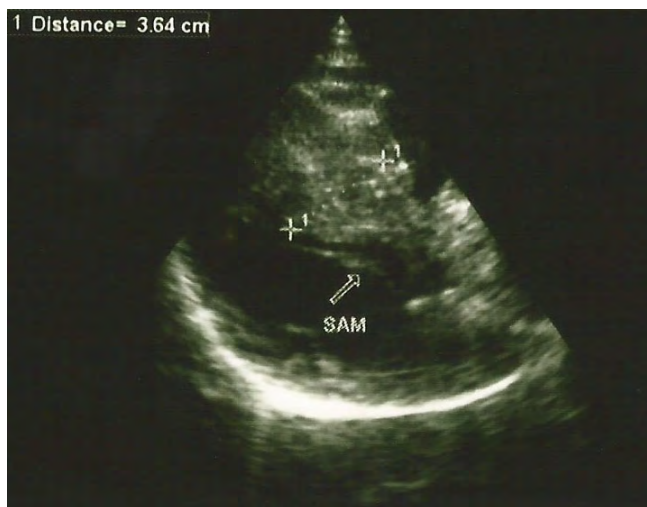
Transthoracic echocardiography showing non-obstructive hypertrophic cardiomyopathy and diastolic septal thickness.
